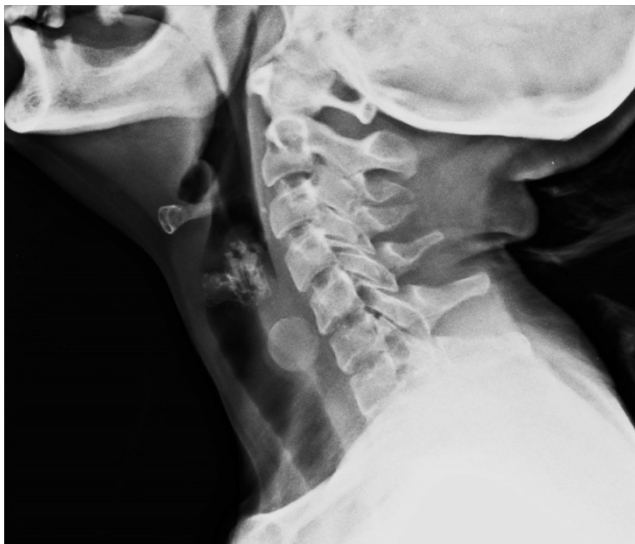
X-ray STN lateral view showing rounded radio-opaque shadow opposite to C5-C6
